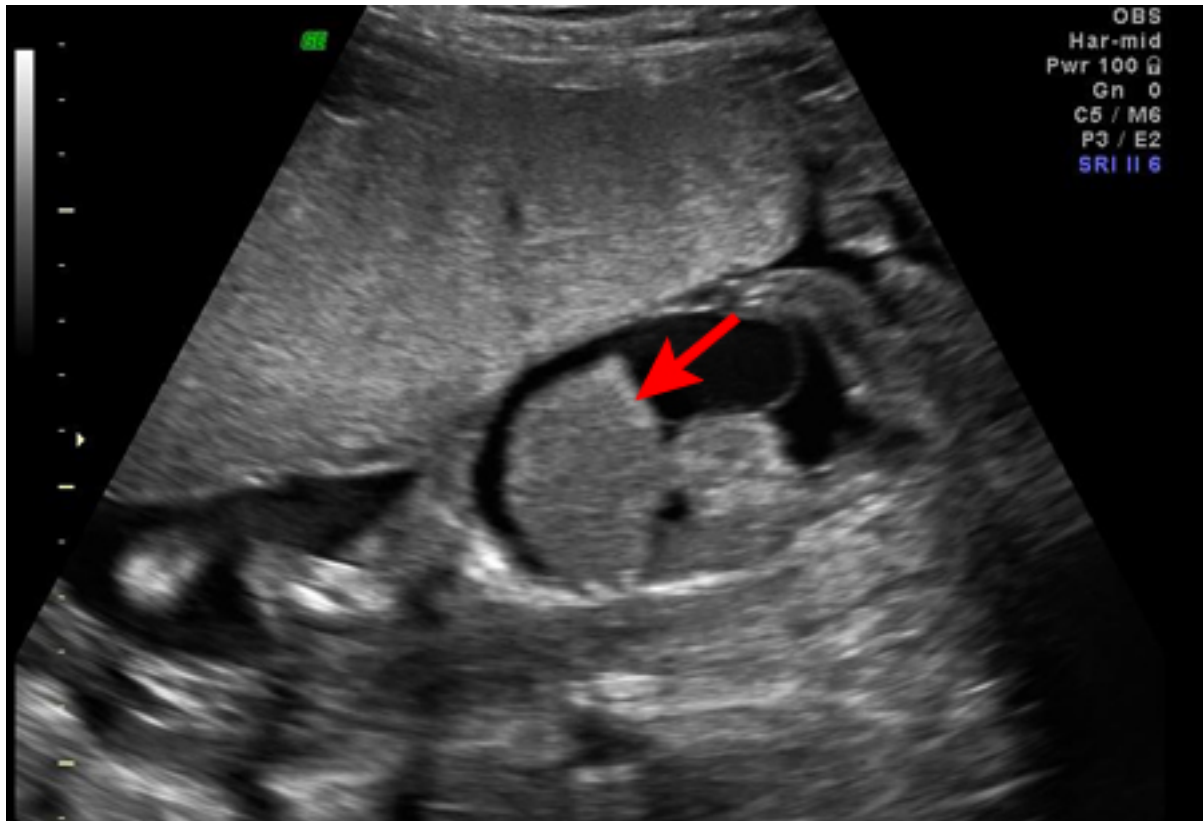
Fetal hydrops, with ascites and hepatomegaly (arrow) diagnosed on antenatal ultrasound
